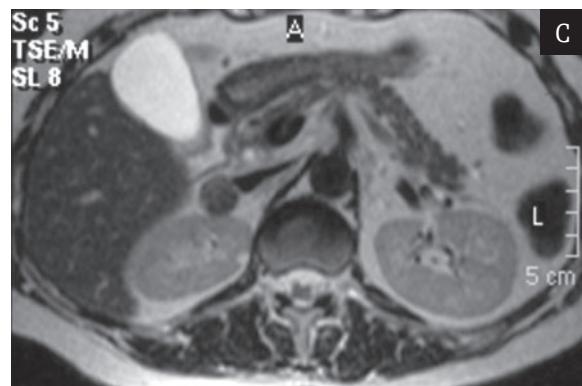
45-year-old patient with right-sided surgically confirmed adrenal adenoma. A. On in-phase image the adrenal mass presents a homogeneous signal intensity (SI: 303). B. The opposed-phase image shows a lower signal intensity (SI: 213) compared with the in-phase image; however, the suppression is slightly heterogeneous; CSI ratio: 0.29. C. Transverse T2-weighted image shows the adrenal tumor as isointense to the liver (adrenal mass SI: 235, liver SI: 251); T2 index: 0.94.
